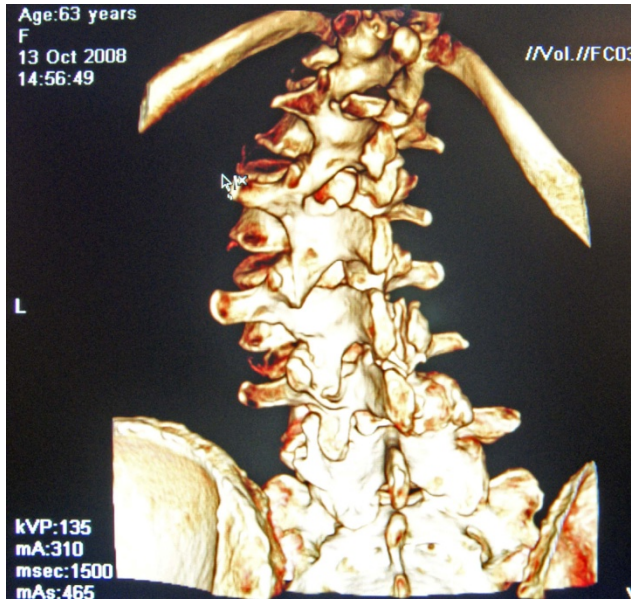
is a PA 3D CT image. It again helps us appreciate the degree of curvature and rotation in this patient's spine.
